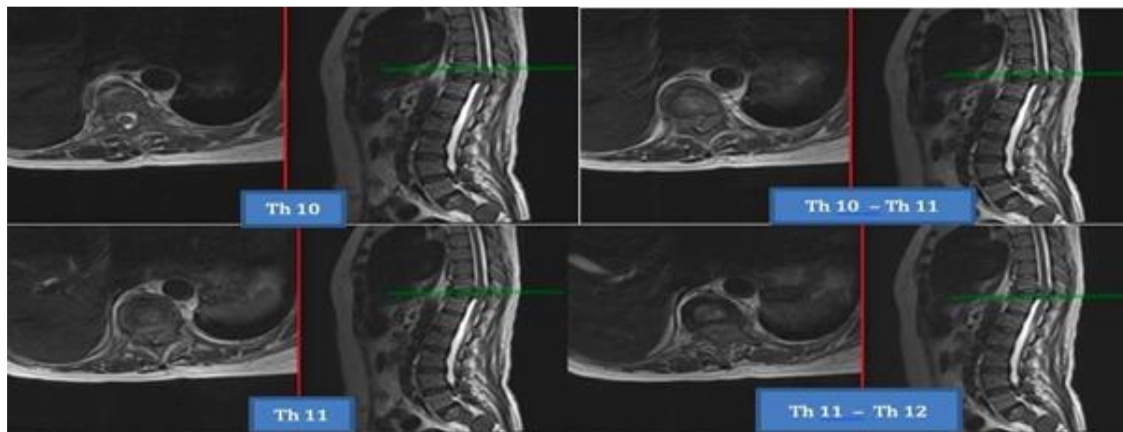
T2W Axial view of MRI
